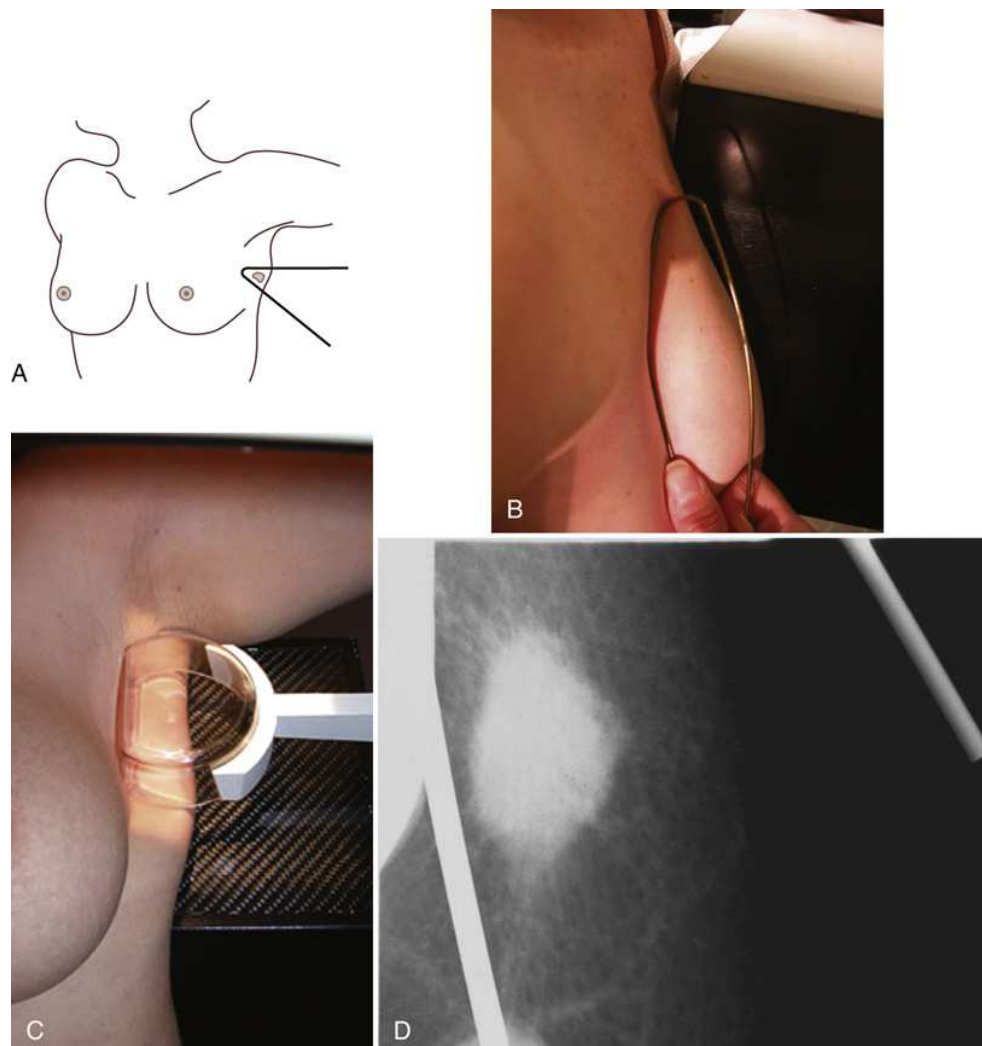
Coat-hanger projection. (A and B) A slippery lesion is captured for imaging by the angle of a wire coat-hanger. (C) Inverted spot compression device can sometimes achieve the same results. (D) Radiograph of lesion imaged using coat-hanger projection. This lesion could not be viewed on routine projections because of its position within the breast and the elastic nature of the lesion, which was determined to be a cancer on biopsy.
